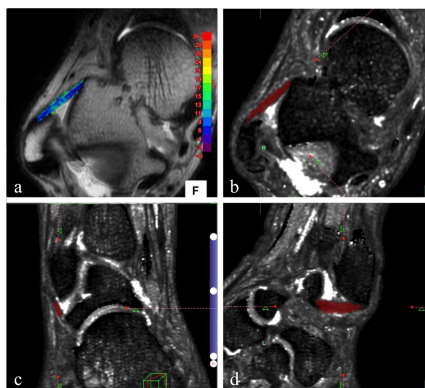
(a) Fusion oblique axial image of 3D T2-weighted image and T2* map image (color map); (b, c, d) T2* map reconstructed images: oblique axial image, oblique coronal image, and oblique sagittal image. Red regions show the anterior talofibular ligament
